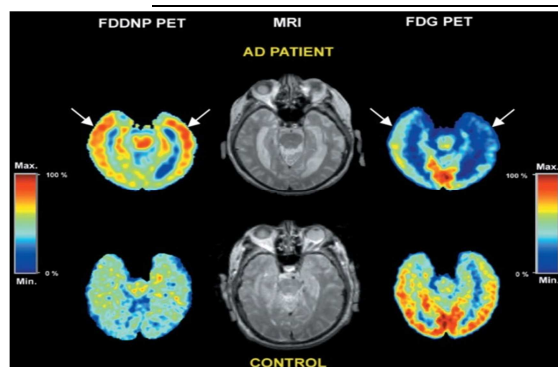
The  $^{18}\text{F}$ -FDDNP-PET, MRI, and FDG-PET images for a representative AD patient (the top row) and an HC (the bottom row). The  $^{18}\text{F}$ -FDDNP images were acquired by summing frames 12-14, corresponding to 25-54 minutes post- $^{18}\text{F}$ -FDDNP injection. The FDG images were obtained by summing frames corresponding to 20-60 minutes post-FDG administration. The arrows display that brain areas with FDG low glucose metabolism are matched with the localization of NFTs and Aps resulting from  $^{18}\text{F}$ -FDDNP binding. Reproduced with the permission from ref. (14). PET, positron emission tomography; MRI, magnetic resonance imaging; AD, Alzheimer's disease; HC, healthy control; NFTs, neurofibrillary tangles; Aps,  $\beta$ -amyloid plaques[13].
